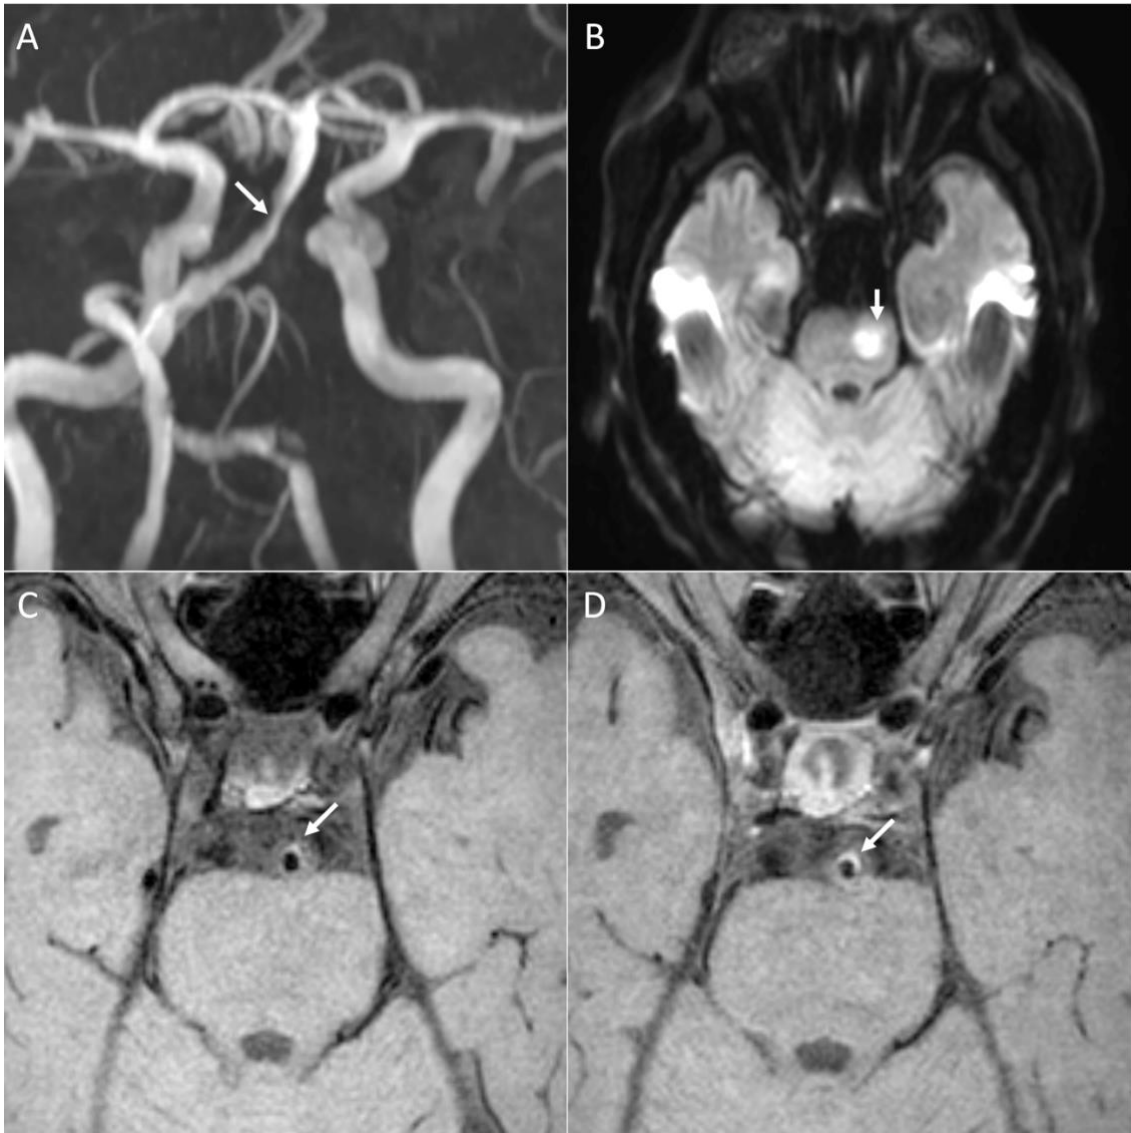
A typical case of a symptomatic atherosclerotic plaque in the BA. A, a symptomatic atherosclerotic stenosis of the BA on MRA imaging (white arrow). B, acute infarction in the BA territory on DWI (white arrow). C and D, an eccentric, focal plaque in the BA as a symptomatic atherosclerotic lesion before and after administering contrast on T1w imaging, respectively (white arrows). BA, basilar artery; DWI, diffusion-weighted imaging; MRA, magnetic resonance angiography; T1w, T1-weighted.
